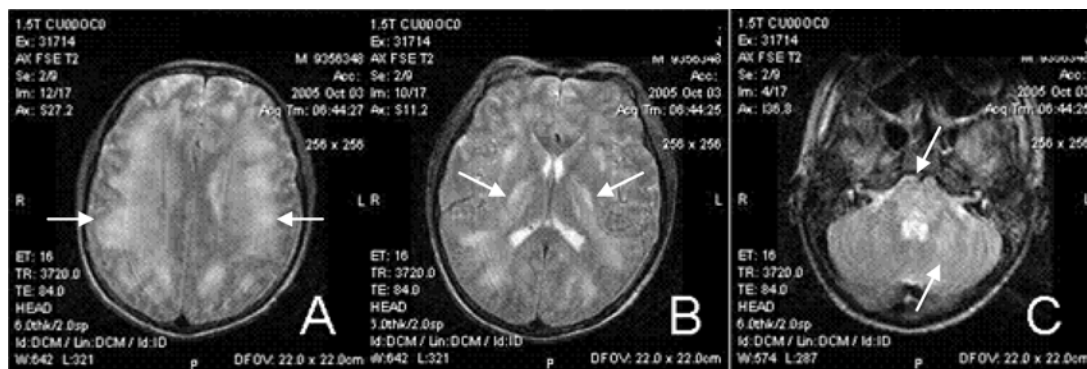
Severe extensive RPLE: T2-weighted MRI of Patient 7, the images showed hypersignal intensity (A) widespread cortical-subcortical area, (B) internal capsules, (C) cerebellum and pons (arrows)
